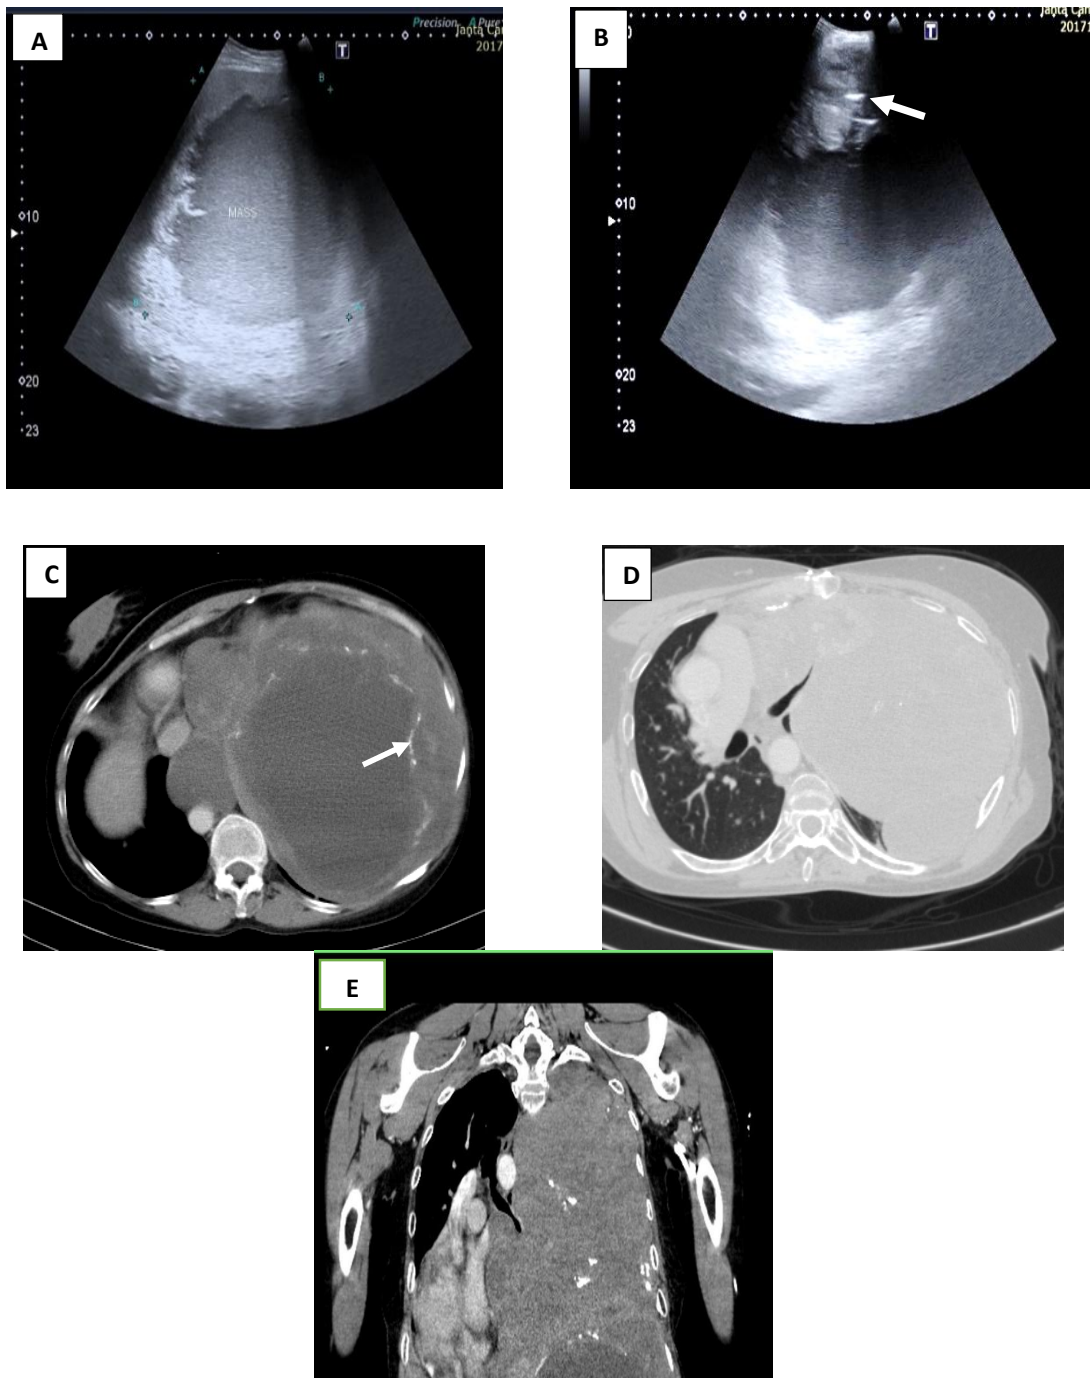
A 38 years old female patient, complaining of severe dyspnea, chest pain and cough, with history of breast cancer. (A & B) Chest US images: Large heterogenous mass with mixed solid and cystic component and calcifications (arrow). It was seen occupying the whole left lung with no sliding, it measures (19x18 cm) (C & D) Post contrast CT axial view, mediastinal and lung windows showing: Huge heterogeneously enhanced mass occupying nearly the whole left lung Fig E (coronal plane), with mixed solid and cystic component and calcifications inside, invading the left main bronchus measuring 19 x12 cm, shifting the mediastinum to the contralateral side
